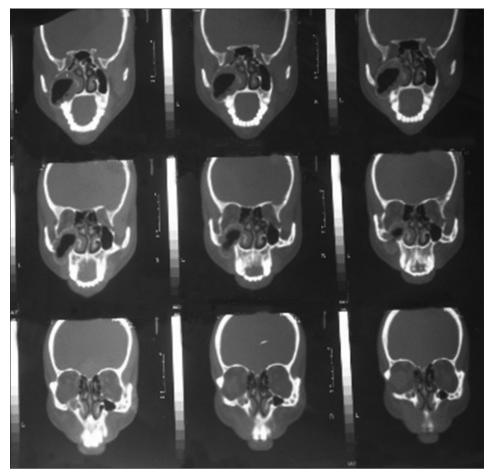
CT showed bulging of the floor of the left maxillary sinus with erosion of dental sockets of the left maxilla associated with mucosal thickening in left maxillary sinus
